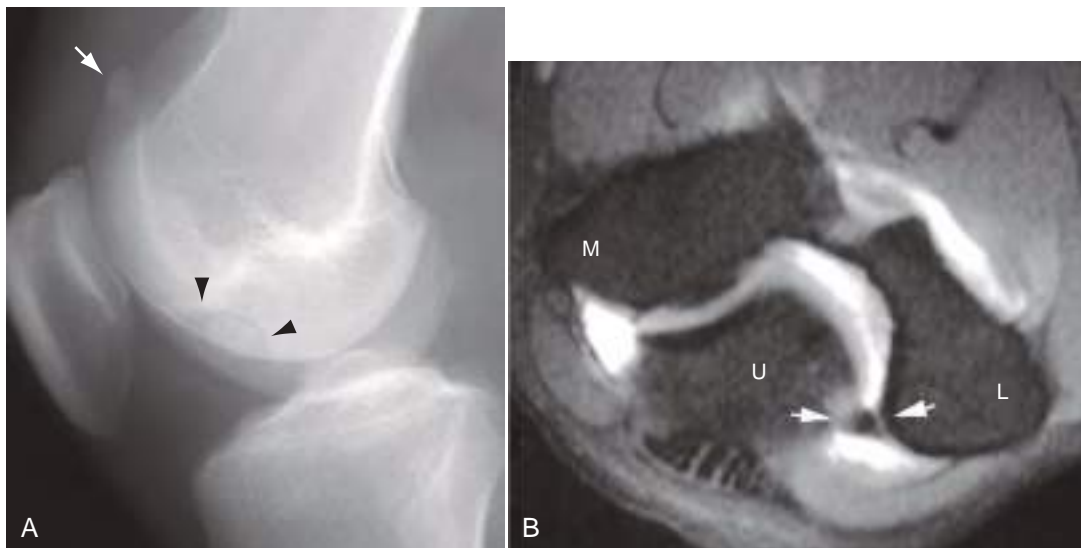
Intraarticular bodies. (A) Lateral knee radiograph shows a small bone fragment in the superior joint recess (*arrow*). Also note the donor site of this osteochondritis dissecans fragment on the medial femoral condyle defect (*arrowheads*). (B) Elbow intraarticular body diagnosed by use of MR arthrography. Axial fat-suppressed T1-weighted MR arthrogram shows a small filling defect (between *arrows*) between the ulna and humerus in the lateral aspect of the olecranon fossa. This body caused pain on the elbow extension and therefore was removed. L, Lateral epicondyle; M, medial epicondyle; U, ulna.
